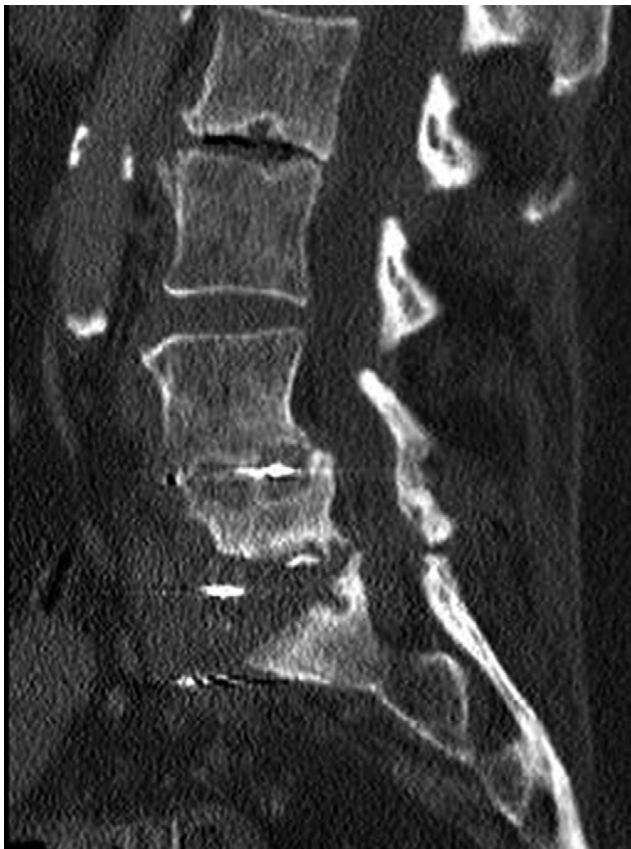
CT scan, sagittal view, of patient presenting with dislodged interbody spacer and infection.
